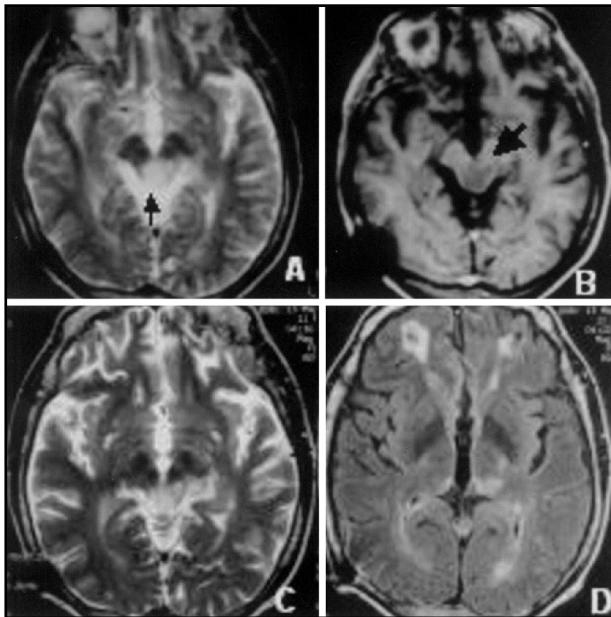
A, B - Preoperative T2 and T1-weighted MRI showing the tumor (arrow). C, D - Postoperative MRI (T2 weighted) 2 1/2 years after surgery showing total removal.
